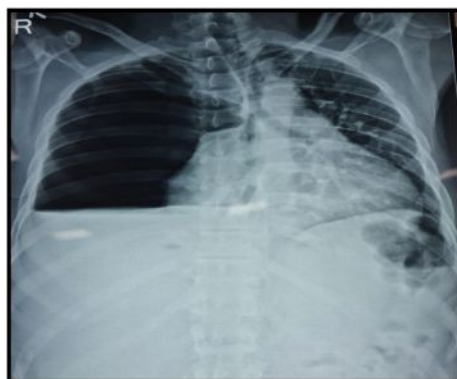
Frontal Chest X-ray showing Right moderate hydropneumothorax with left-sided mediastinal shift and tracheal deviation.
